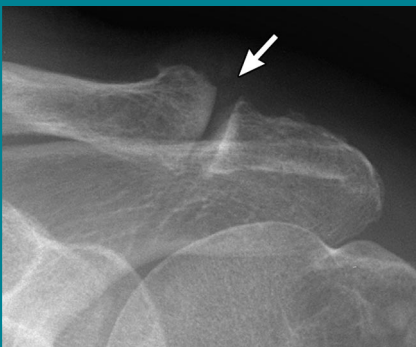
Osteoarthritis. Anteroposterior acromioclavicular joint radiograph shows joint space narrowing, sclerosis, and osteophyte formation involving the acromioclavicular joint (arrow).
